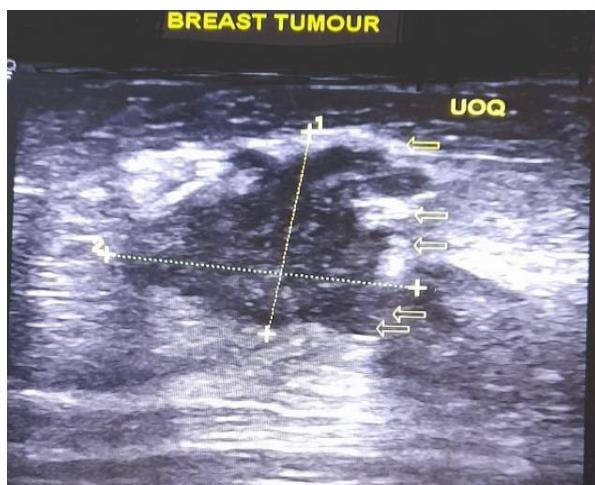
Breast ultrasound - 7.5MHZ linear transducer
